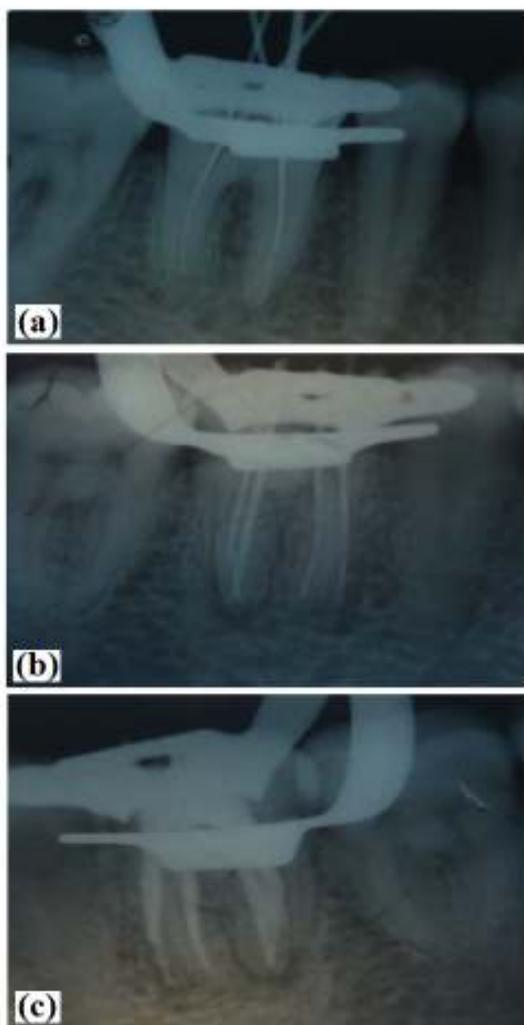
Radiographic presentation of radix paramolaris (a) working length determination (b) Master cone IOPA shows extra root (c) obturation radiograph shows definite separate roots.
